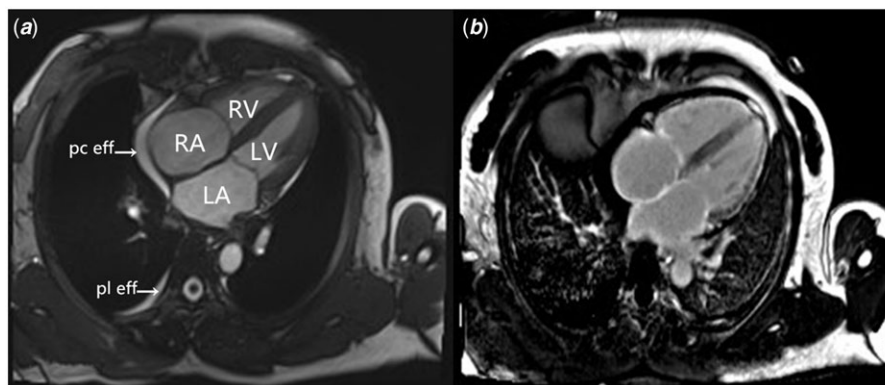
(a) Four-chamber steady-state free precession image shows normal thickness of left ventricular wall (10 mm) and IVS (11 mm), apparent biatrial dilatation and pericardial effusions (Pc eff), which are consistent with results of echocardiography. Mild pleural effusions (Pl eff) is also observed. (b) Four-chamber view from postgadolinium delayed enhancement images show biatrial, tricuspid valve, mitral valve, right ventricle and left ventricle line-, granular- or patchy-like enhancement.
